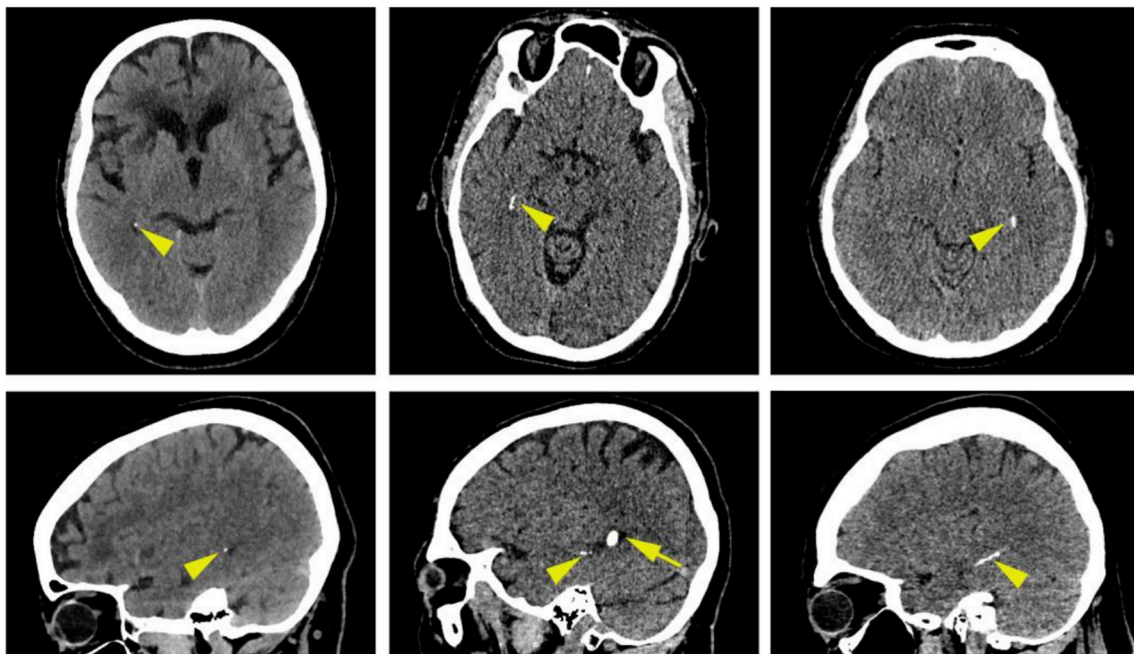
Examples of mild, moderate and severe hippocampal calcifications on computed tomography (CT). Hippocampal calcification on thin unenhanced CT examinations (arrowheads), left image mild calcification, middle moderate, right severe. Arrow: choroid plexus calcification.
